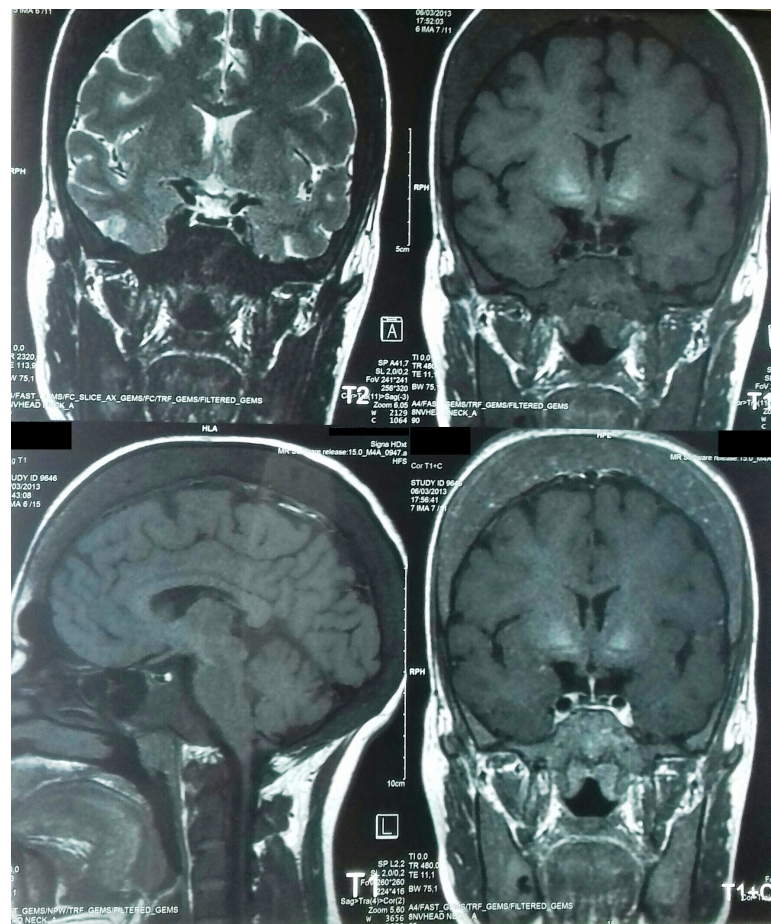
Pituitary MRI scan showed hypoplastic anterior pituitary lobe with markedly decreased signal intensity on T1 and T2 weighted images.
